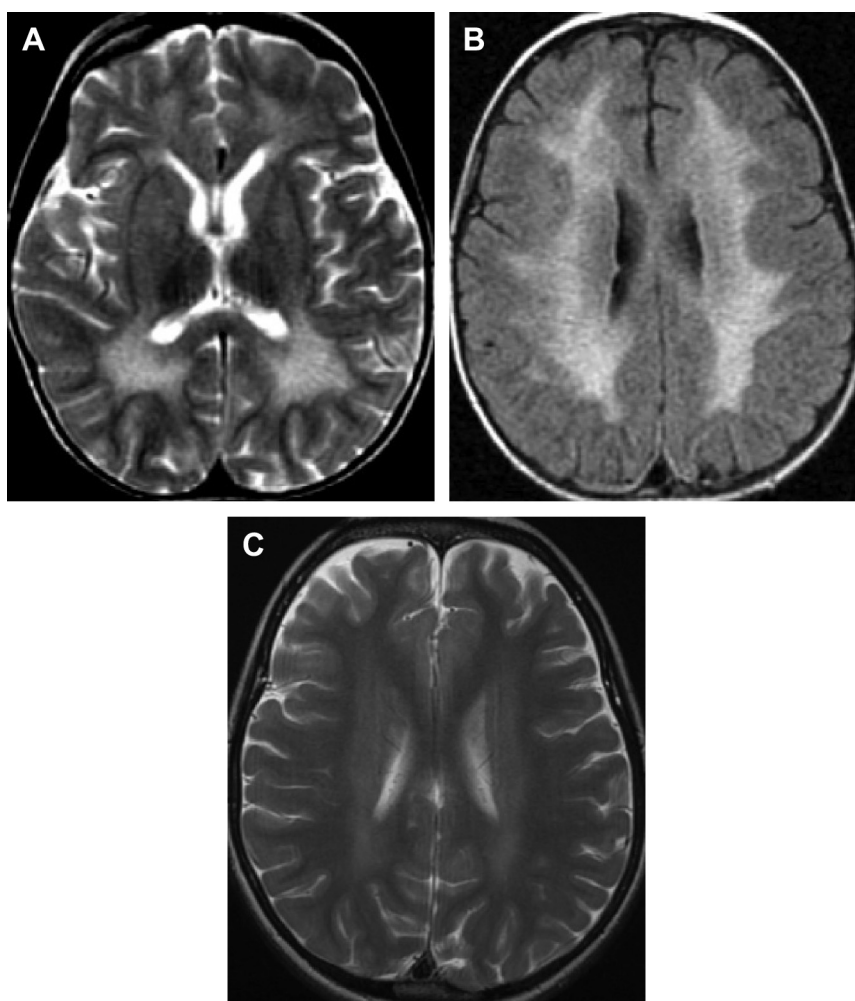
Additional leukodystrophies with central white matter predominance. Three-year-old with metachromatic leukodystrophy, axial Fluid attenuated inversion recovery (FLAIR) (A) and T2 (B) images. Notice the sparing of the subcortical white matter and confluent appearance of the signal abnormality. Faint tigroid sparing can be seen along the perivascular spaces, particular on the FLAIR image. Neuronal ceroid lipofuscinosis typically presents as gray matter volume loss, but central white matter signal increase can occasionally be detected as in this axial T2 image of a 5-year-old girl with CLN8 (C).
